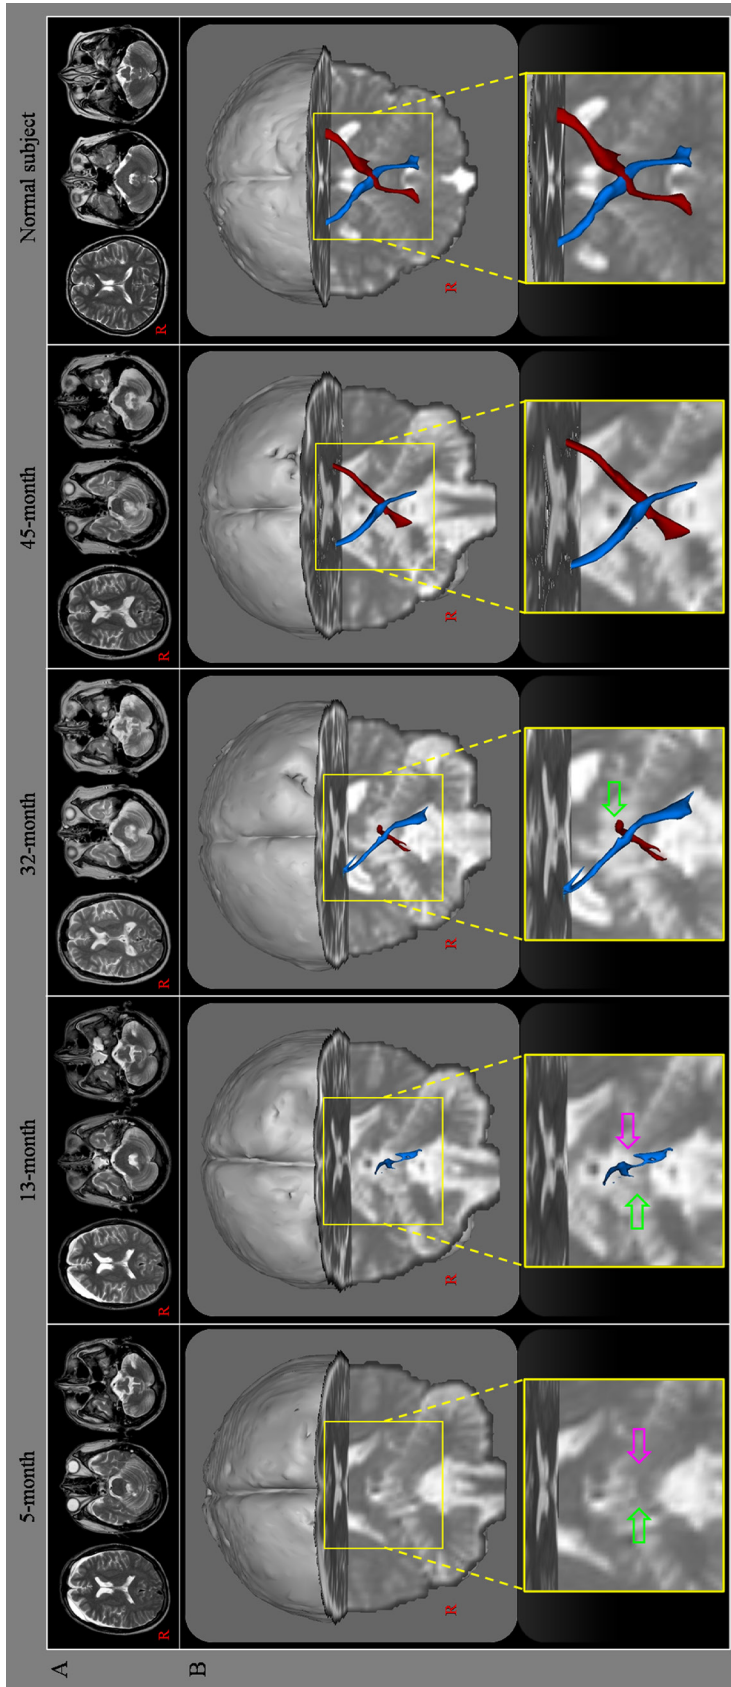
(A) T2-weighted brain MR images show both frontal subdural hygroma and encephalomalacia at the cerebellum. (B) Results of diffusion tensor tractography (DTT) for the dentato-rubro-thalamic tract (DRT). On 5-month DTT, the DRTs in both hemispheres are not reconstructed (right: green arrow, left: purple arrow). In contrast, on 13-month DTT, the lower portion of the left DRT is reconstructed (purple arrow) although the right DRT is not still reconstructed (green arrow). On 32-month DTT, the whole left DRT is reconstructed, however, only the lower portion is reconstructed in the right DRT (green arrow). Finally, both DRTs are reconstructed on 45-month DTT. Results of DTT for the DRT in a normal subject (25-year-old male).
